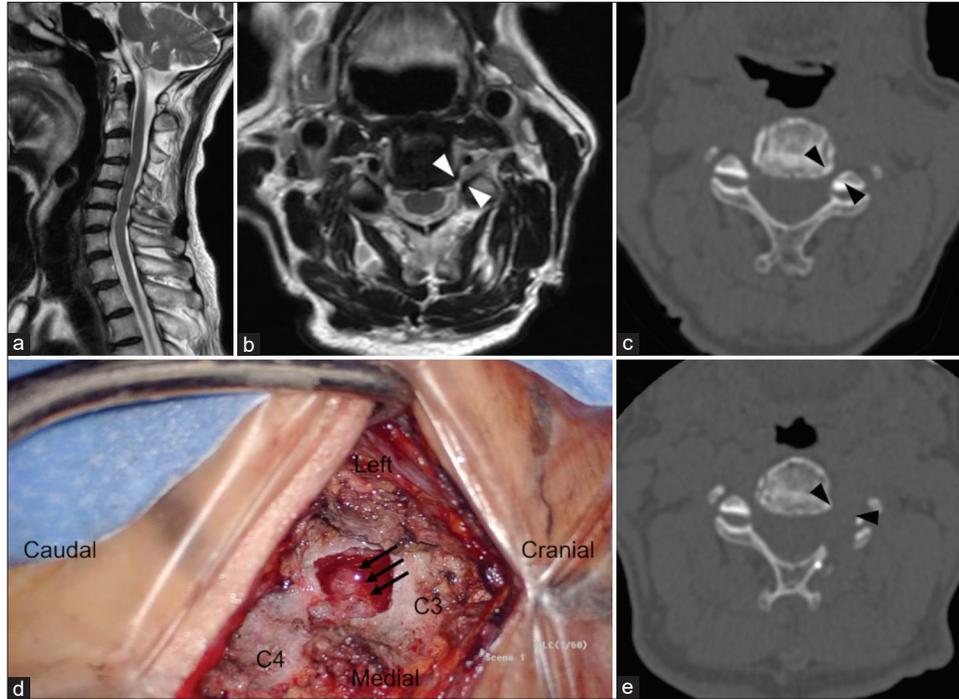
(a) Preoperative sagittal magnetic resonance image (MRI). Apparent cervical spinal cord stenosis is not observed. (b) An axial MRI at the level of the bilateral C4 nerve roots. Left foramen stenosis of the C4 nerve root is visible (white arrow heads). (c) A computed tomography image showing osteophytes causing left foramen stenosis of the C4 nerve root. The ventral and dorsal roots of C4 are compressed (black arrow heads). (d) The left C4 nerve root is posteriorly decompressed (triple arrows). (e) A postoperative computed tomography image showing release of the left C4 nerve root (black arrow heads).
